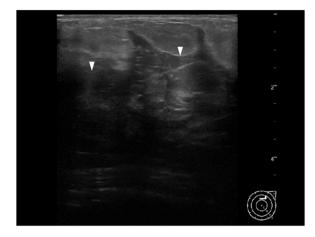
Breast Ultrasound. Ultrasonography revealed a diffuse hypoechoic area within the mammary gland (arrowheads).
